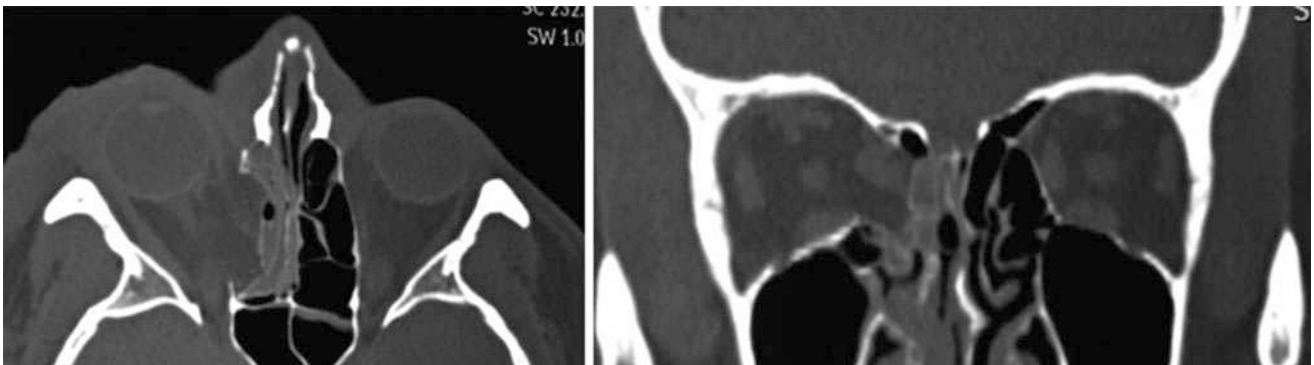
CT scan, axial and coronal bone windows: Large right medial wall blow-out fracture with orbital fat and medial rectus prolapse and opacification of the ethmoid sinus
